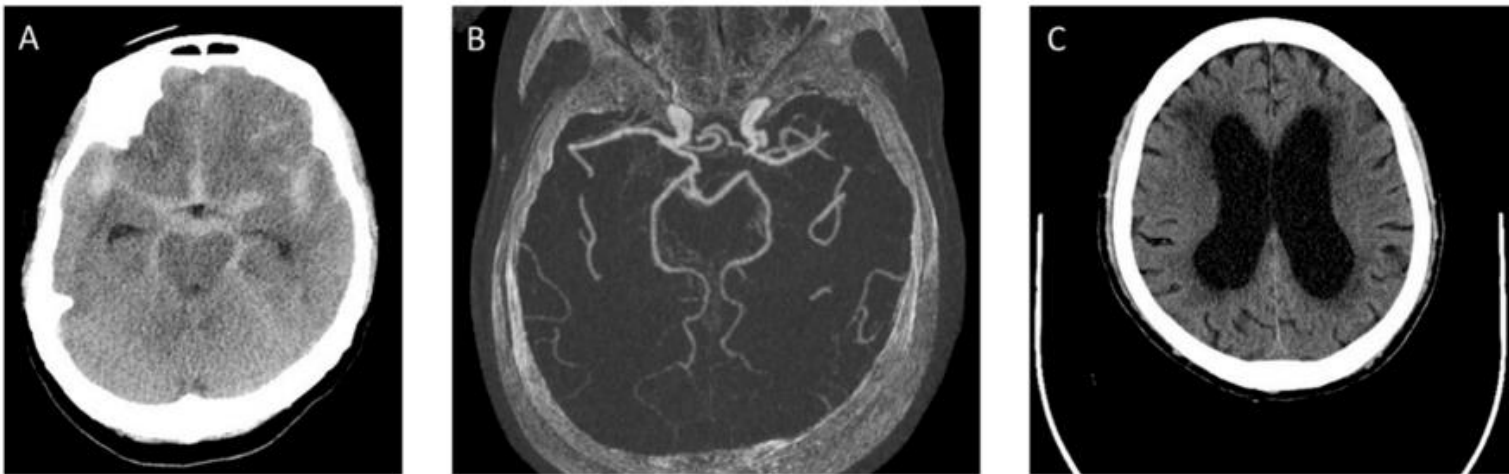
The series of computed tomography (CT) images of a case with aSAH. (A) A 68 years-old female patient presented with SAH at admission. There is no IVH and no acute hydrocephalus; (B) a ruptured left posterior communicating artery aneurysm was identified and coiled; (C) on 12 days after aSAH, CT showed hydrocephalus. She developed progressive ataxia and cognitive dysfunction.
